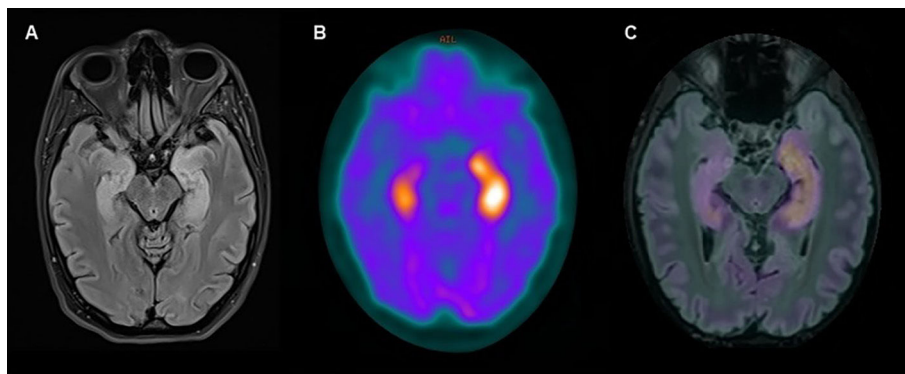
Fusion of brain MRI and 18F-FDG PET. Fusion of brain MRI and 18F-FDG PET of a patient with antiGAD67 autoimmune encephalitis is shown, axial slides (A) Brain MRI (axial FLAIR sequence): left predominant but bilateral medial temporal lobes hyperintensity can be seen. (B) Brain 18F-FDG PET (axial slide): left predominant but bilateral hippocampus hypermetabolism can be seen. (C) Brain MRI and 18F-FDG PET fusion shows an overlap between T2/FLAIR hyperintensity and hypermetabolism.
